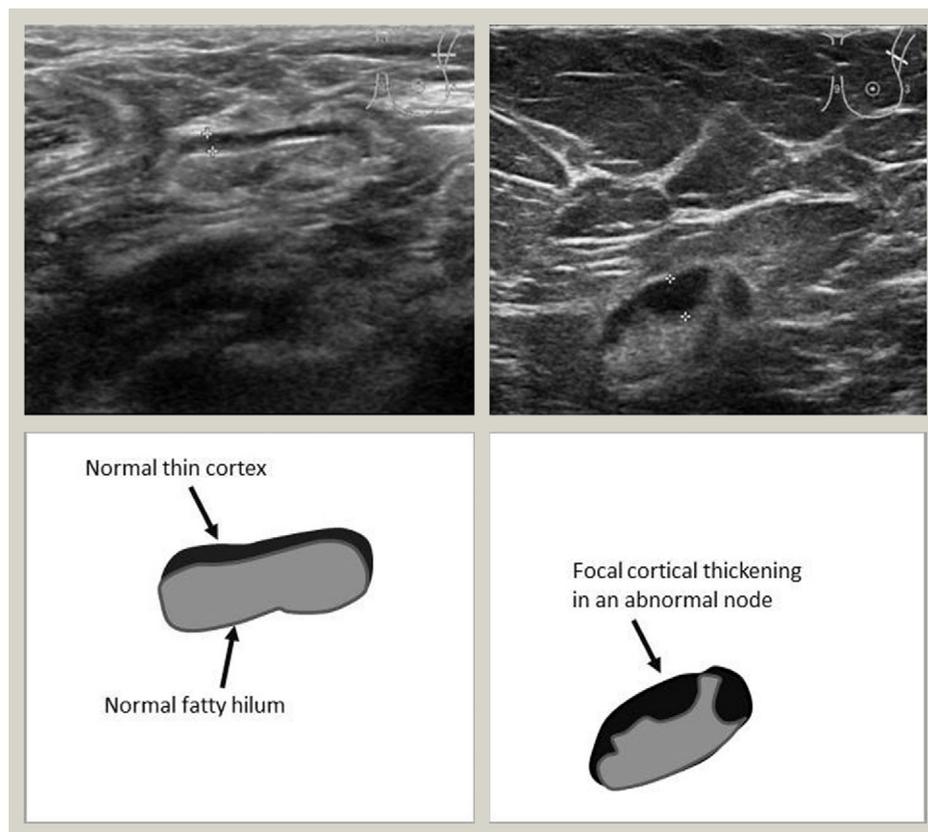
Ultrasound images. Two cases with breast cancers presenting to one-stop clinics. The left image shows a normal lymph node; cortical thickness is less than 1.8 mm which would not reach threshold for a biopsy. The right image shows a lymph node with 3.6 mm of focal cortical thickening. In our unit we would grade this LN4 (suspicious). A core biopsy targeted to this thickened cortex confirmed metastasis.
